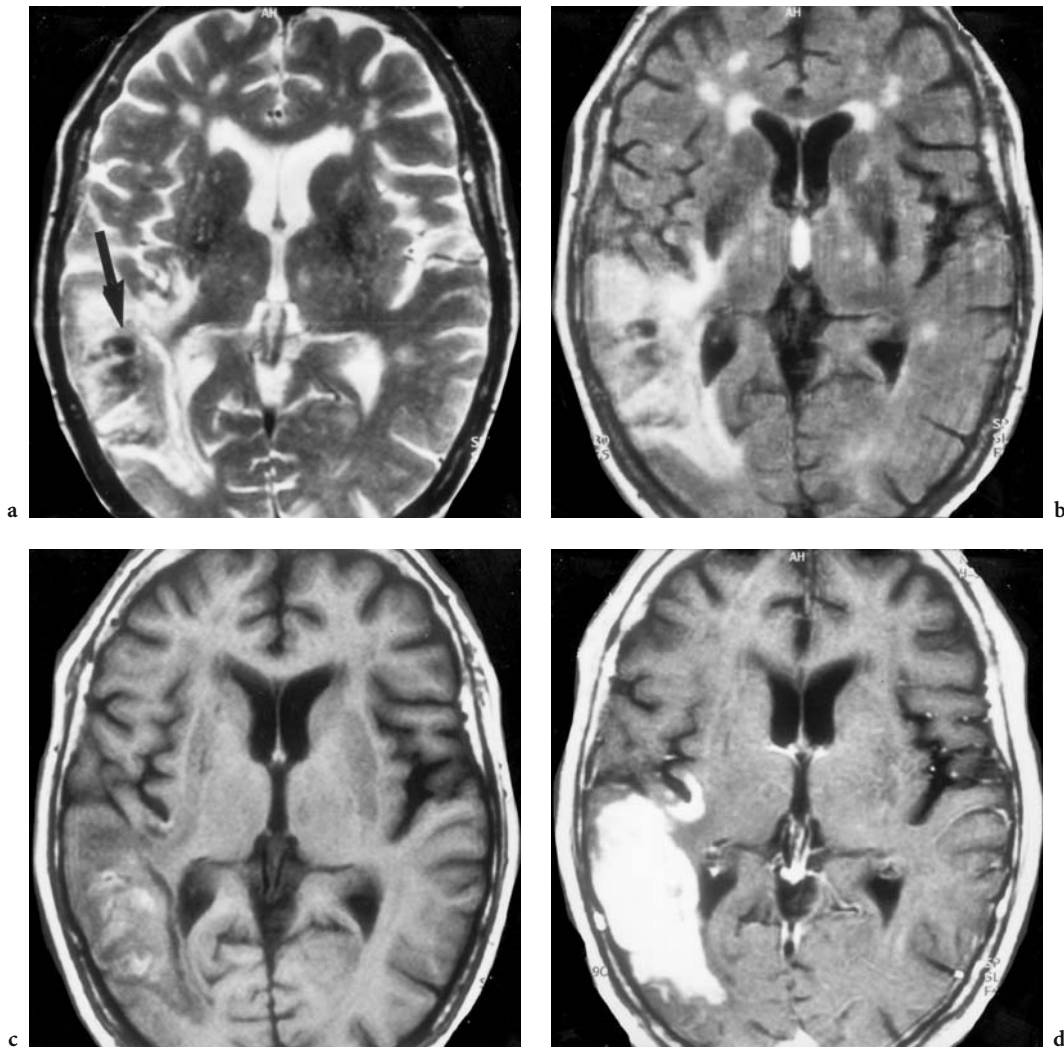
A 77-year-old woman with atrophy of both papillae and hemianopia to the left of unknown duration. Diagnosis: acute hemorrhagic infarction of the temporo-occipital right ACM territory in vascular encephalopathy. MRI: a axial T2-weighted view with bright signal enhancement of the right temporo-occipital parenchyma, in addition to several lacunar subcortical and thalamic infarctions. Note hypointensity (*arrow*) of the cortex and in the subcortical temporal region, corresponding to susceptibility disturbance caused by fresh to subacute blood. b Corresponding T2-weighted FLAIR image, where the infarction is more distinctly differentiated from the older lacunar defects. c T1-weighted native view with the hyperintense region (methemoglobin) of the hemorrhagic portion of the infarct area. d Corresponding T1-weighted, contrast-enhanced image with bright BBB disruption of the entire infarct area, corresponding to a 2- to 3-week-old infarction
